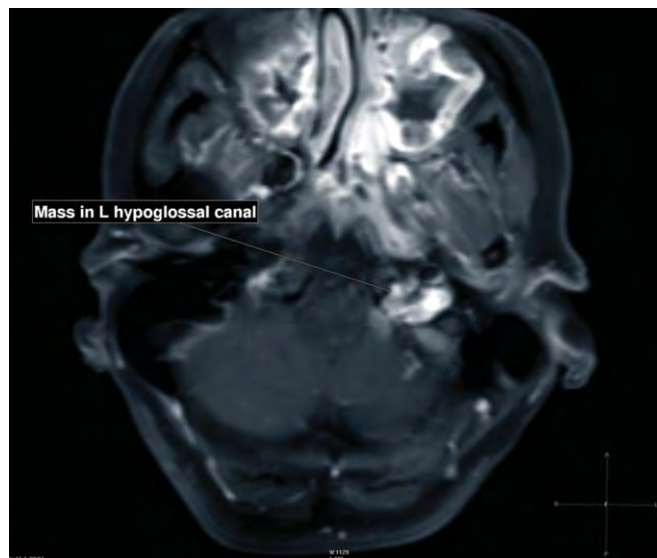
MRI T1 weight axial slice of posterior cranial fossa showing mass in left hypoglossal canal.
